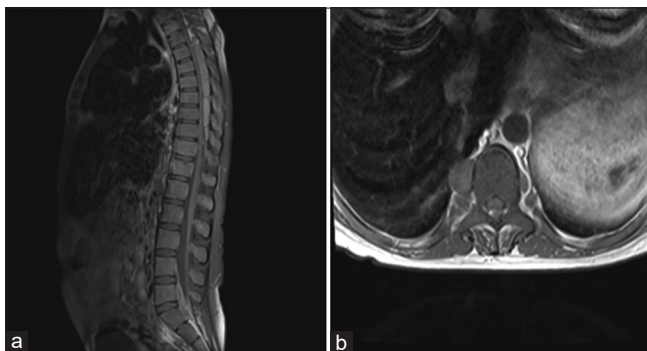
(a) Sagittal postcontrast T1 with fat sat-weighted image showing low bone marrow signal intensity, enhancing posterior epidural masses in the thoracic region which are isointense signal to bone marrow compressing the thoracic cord. Similar masses in the ventral epidural space at the lumbosacral spine. (b) Axial T1-weighted image showing paraspinal masses isointense signal to bone marrow
